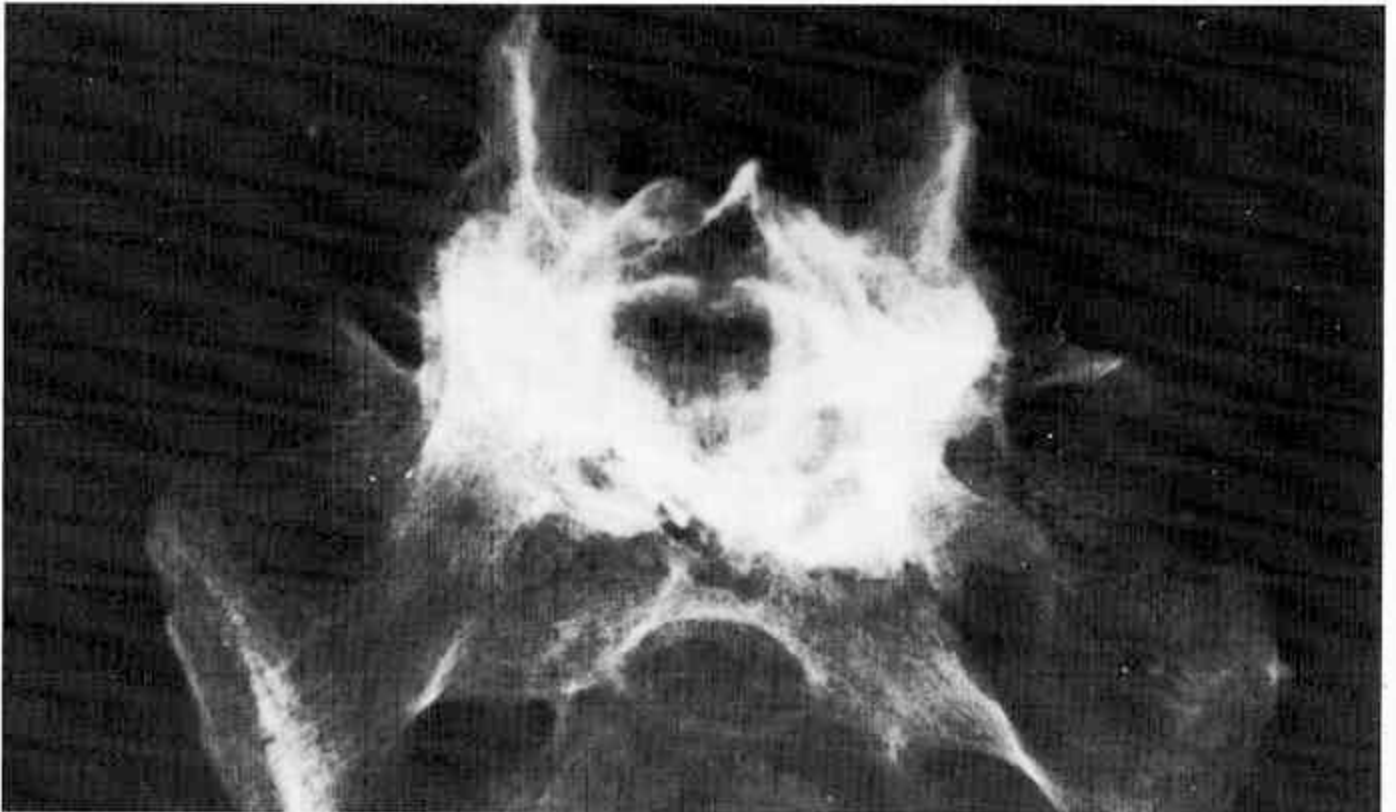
X-ray showing vertebral fusion of L5-S1.
